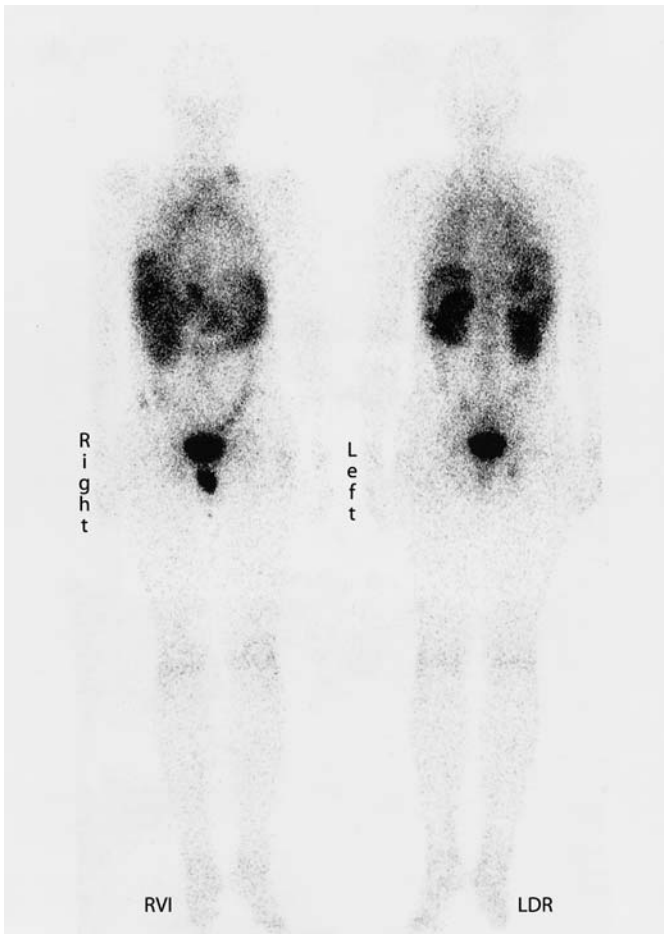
Cholecystinin-B/gastrin receptor scintigraphy with ^{111}In -labeled DTPA-D-Glu¹-minigastrin in a 34-year-old patient with advanced metastatic MTC, showing intense uptake in lymph node, diffuse lung, bone (marrow), and liver metastases. Physiological uptake is confined to the stomach, as the organ with the highest normal CCK-B receptor expression, and the kidneys, as excretory organs
